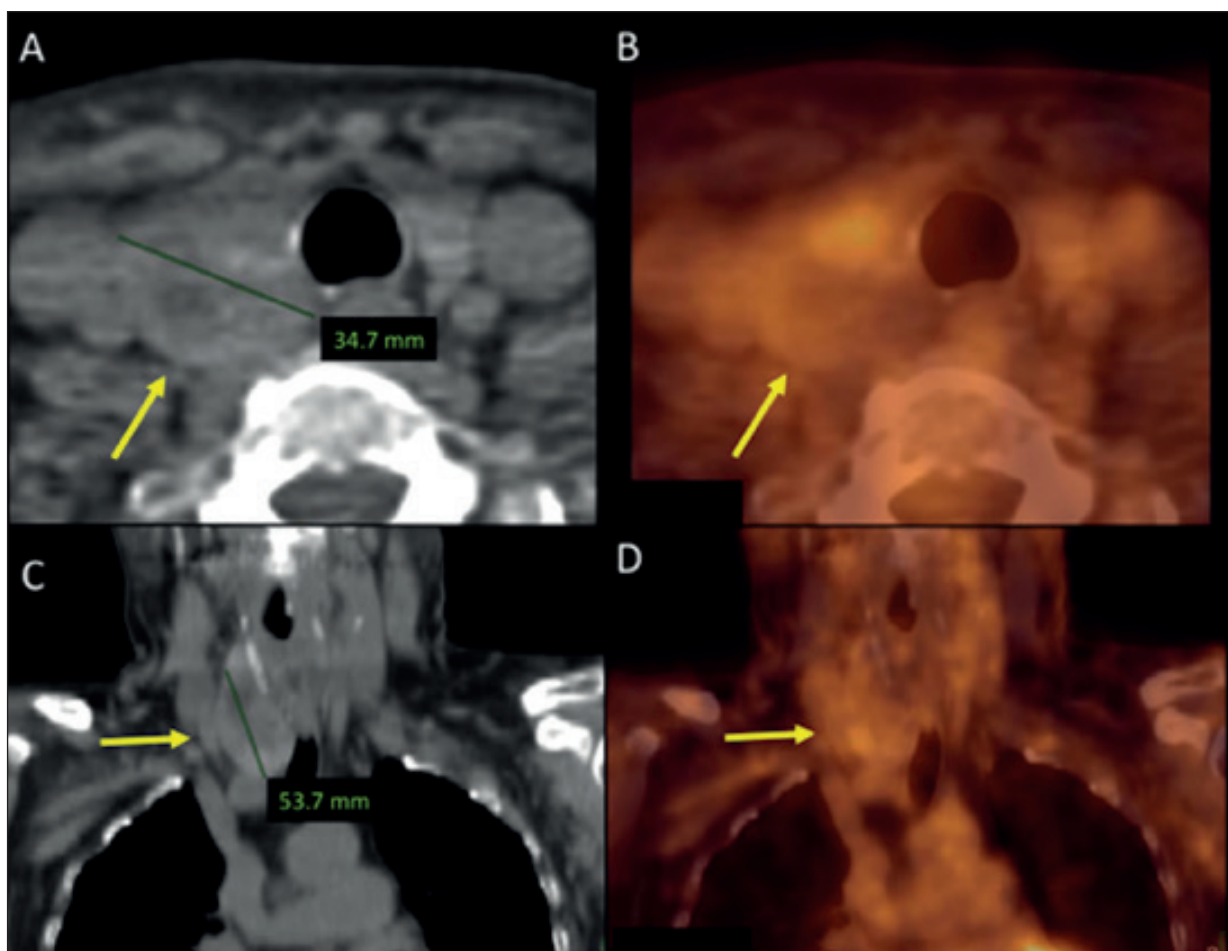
Incidental finding in a 69-year-old multiple myeloma patient who underwent [^{18}F]FDG-PET/CT for post-therapy (chemotherapy and immunosuppressive therapy) restaging. A large right thyroid lobe nodule (53.7x34.7 mm) involving thoracic inlet, classified as nM3-IF (yellow arrows), was detected on co-registered CT (A, axial and C, coronal reconstructions), which did not show [^{18}F]FDG-uptake on (B) axial and (D) coronal fused PET/CT images.
